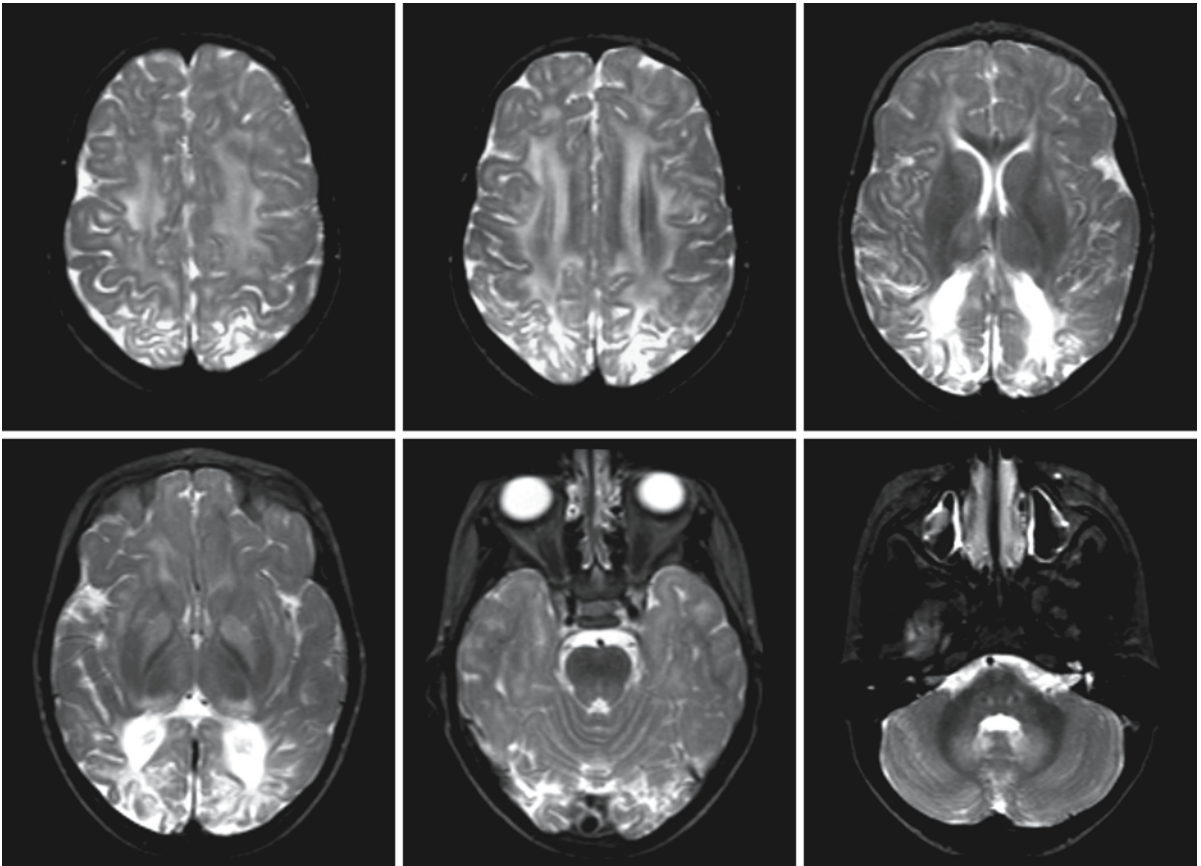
This 4-year-old girl with HMG-CoA lyase deficiency experienced serious hypoglycemia in the neonatal period. She is severely retarded and has a visual impairment and microcephaly. MRI shows damage of the parieto-occipital white and gray matter, as may occur after neonatal hypoglycemia. In
